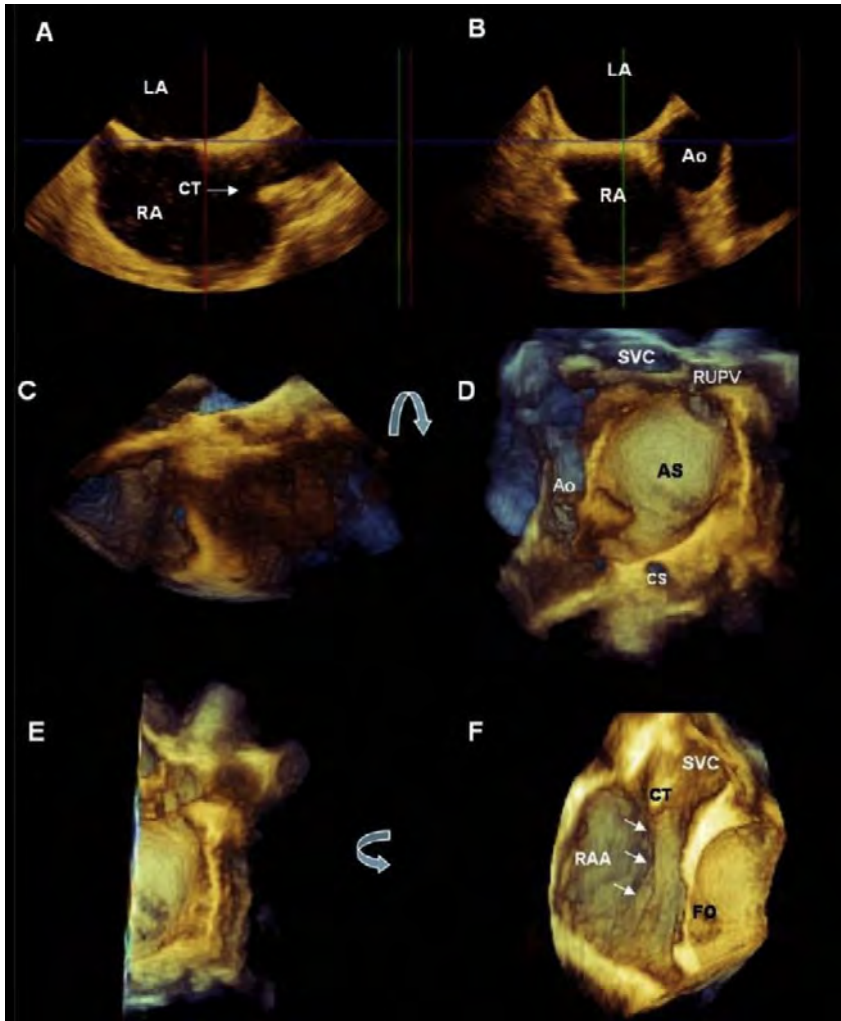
静态图像显示两个互相垂直的二维 TEE 平面(A 和 B)以获取放大的 IAS 3DE 数据(C)。将探头上-下旋转 90° (弯曲箭头)(D), 可获得房间隔左侧正面成像。可对图像 D 进行切割, 去除左侧半的房间隔(E), 逆时针旋转探头 90° (弯曲箭头)(F), 从 SVC 到 IVC 的整个界嵴(箭头)都可以显示出来。Ao, 主动脉; AS, 房间隔; CS, 冠状静脉; CT, 界嵴; FO, 卵圆窝; RAA, 右心耳。
